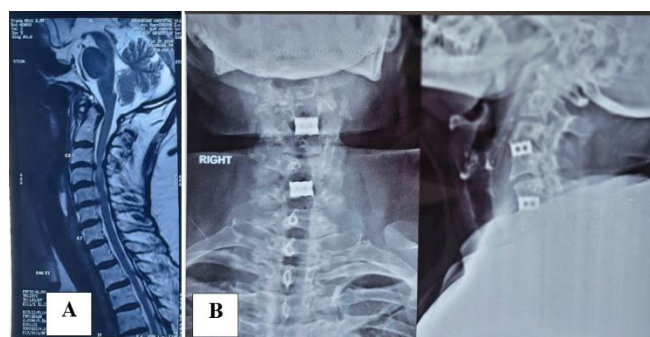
A: Sagittal view of cervical spine MRI suggestive of C3-C4 & C5-C6 Diffuse disc bulge and Hyperintense signal intensity at C3-C4 level; B: Post-Operative X-ray of 2 level ACDF
